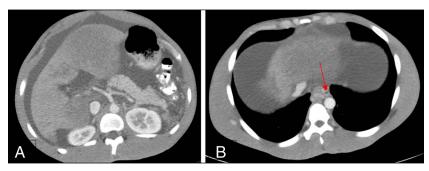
Abdominal computed tomography. (A) Diffuse anasarca and ascites. Also seen is small bowel wall thickening with decreased lumen size—indicative of small bowel congestion related to portal vein and hepatic vein thrombosis. (B) Esophageal varices (red arrow).
